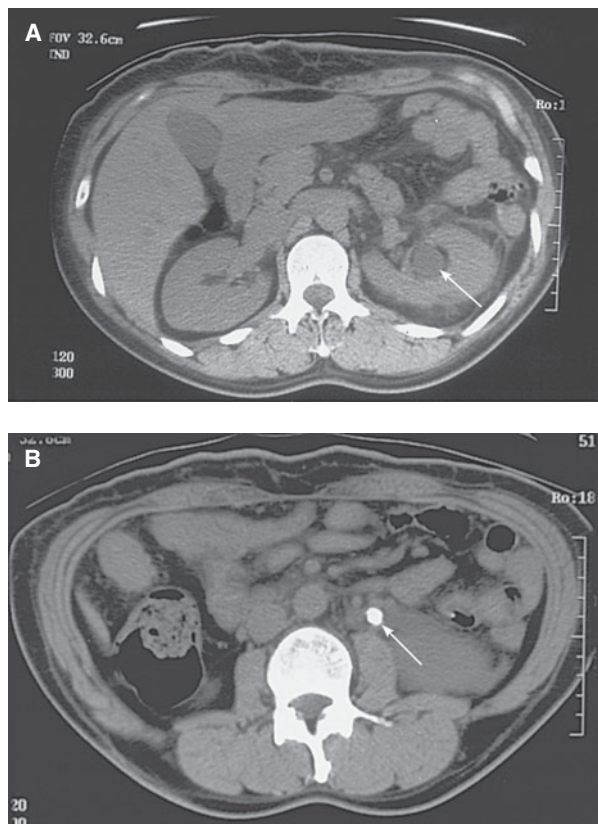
CT scan of a kidney stone causing obstruction. Shown in panel A is the dilated renal pelvis (*arrow*) and in panel B the obstructing calculus in the ureter (*arrow*).
